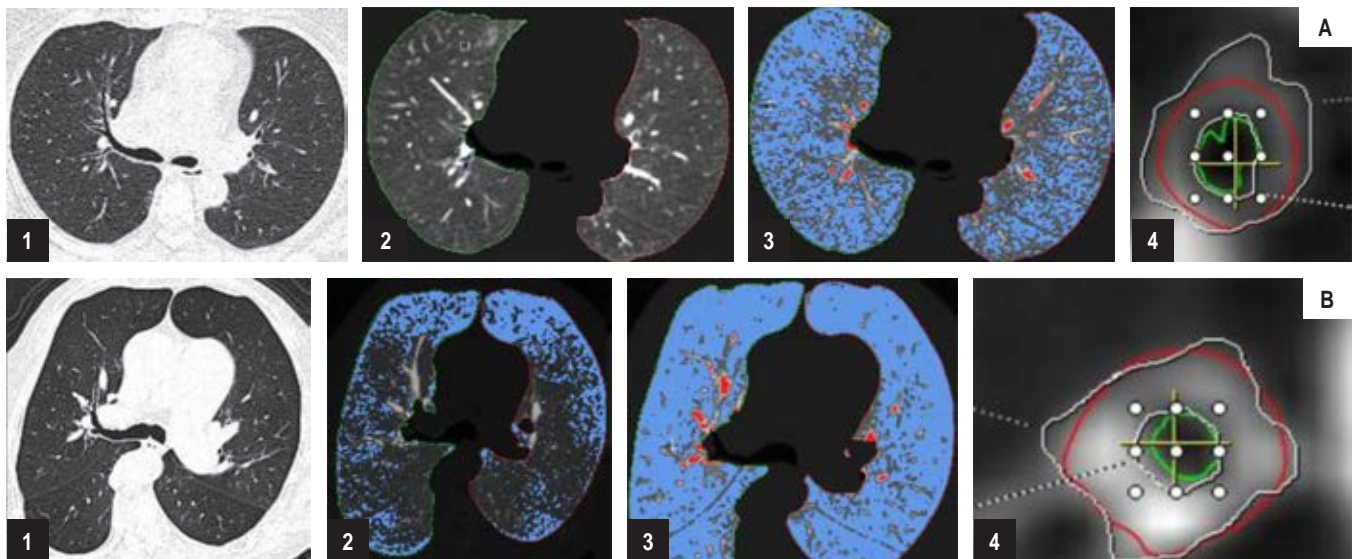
Parametric computed tomography map in patients with wood smoke damage at different stages of the disease. A) A CT scan of a patient exposed to wood smoke, chronic bronchitis without spirometric obstruction is shown: with normal high-resolution CT in A1; in A2 PM with volume of 3,960 mL and practically null emphysema index of 0.9%; in A3 MPR expiratory with air trapping of 40.9%, and %AP in A4 of 0.81. His PFTs are characterized by increased small airway resistances on oscillometry (R5Hz 146% pred, R20Hz 130% pred, R5Hz-R20Hz 0.15 KPa L/s). B) A CT scan of a COPD GOLD 2 patient exposed to wood smoke, chronic bronchitis is shown: the CT scan demonstrates in B1 mosaic pattern, low attenuation centrilobulillar nodules and an increase in the anteroposterior axis of the rib cage; in B2 PM with volume of 3,973 and emphysema index of 25%; B3 PM significant expiratory air trapping of 75.8% and in B4 %AP of 0.84. Their PFTs are characterized by increased small airway resistances in oscillometry (R5Hz 265% pred, R20Hz 142% pred, R5Hz-R20Hz 0.6 KPa L/s).
